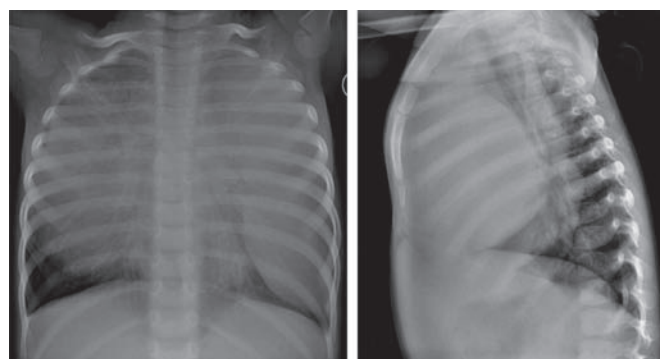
Chest x-ray showing opacification of both lung fields.
